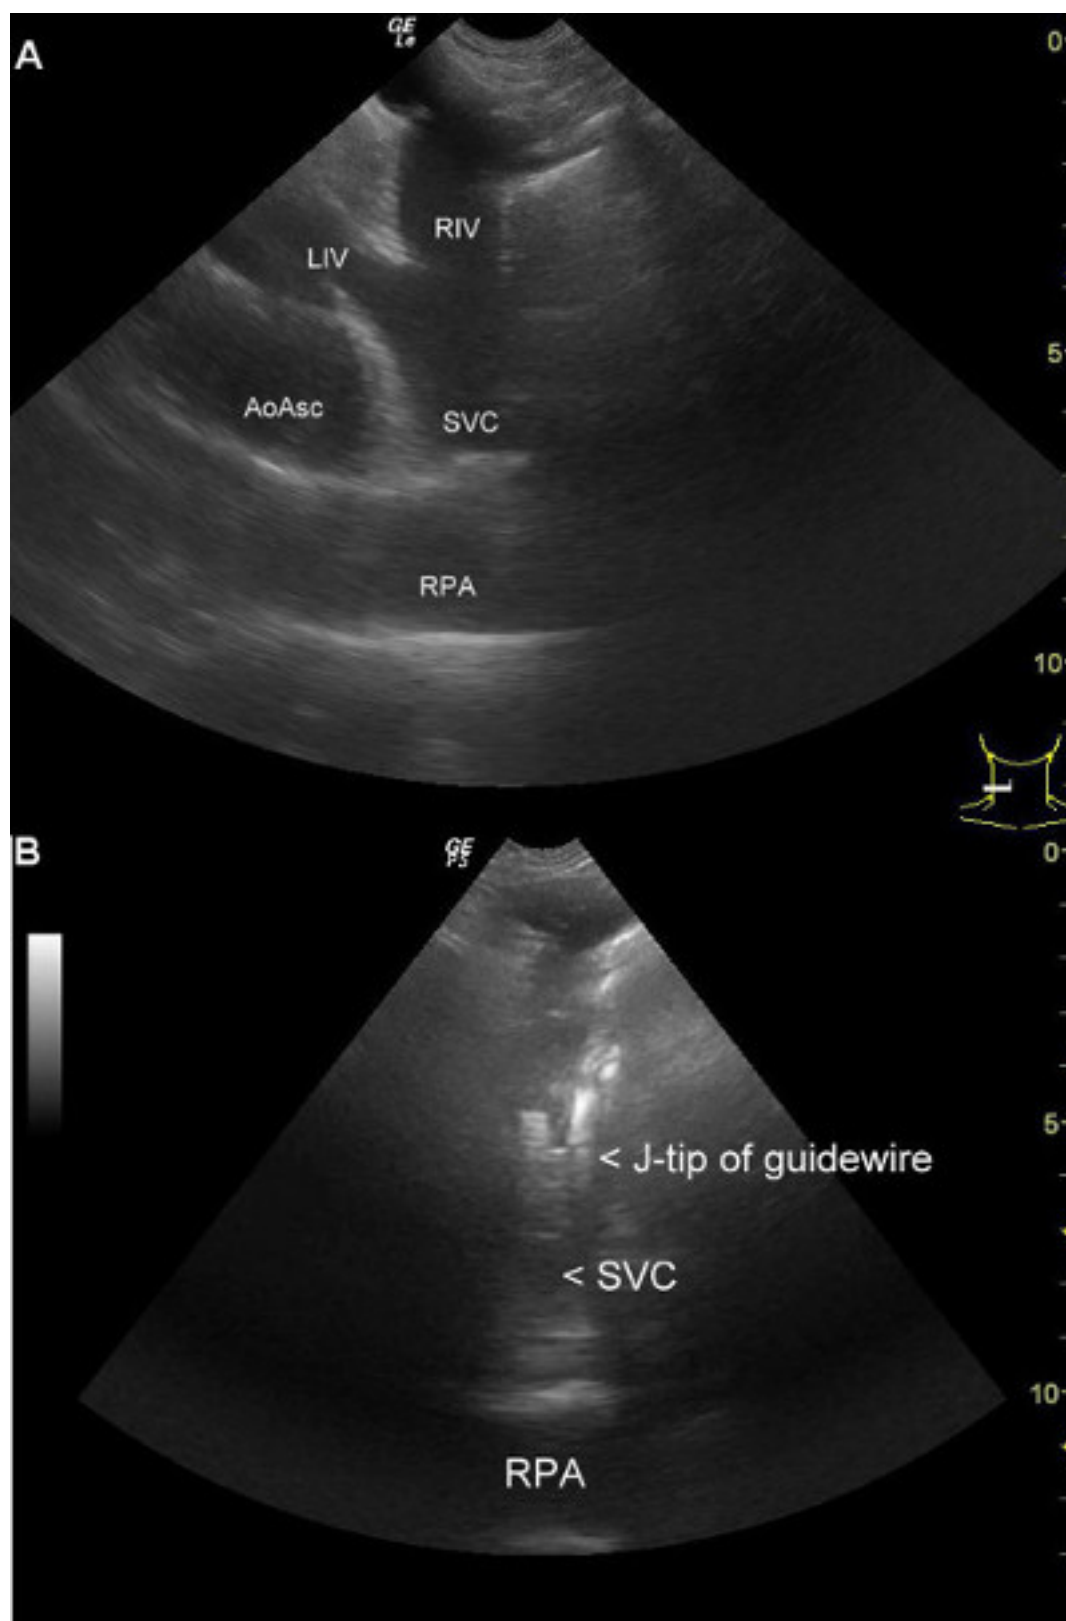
(A) Representative ultrasound image of the superior vena cava (SVC), right and left innominate veins (RIV/LIV), ascending aorta (AoAsc) and right pulmonary artery (RPA). (B) Representative ultrasound-guided guidewire advancement. J-tip of the guide wire is visualized in the mid-portion of the SVC. The RPA can be seen as a hypoechoic band in the far field.
